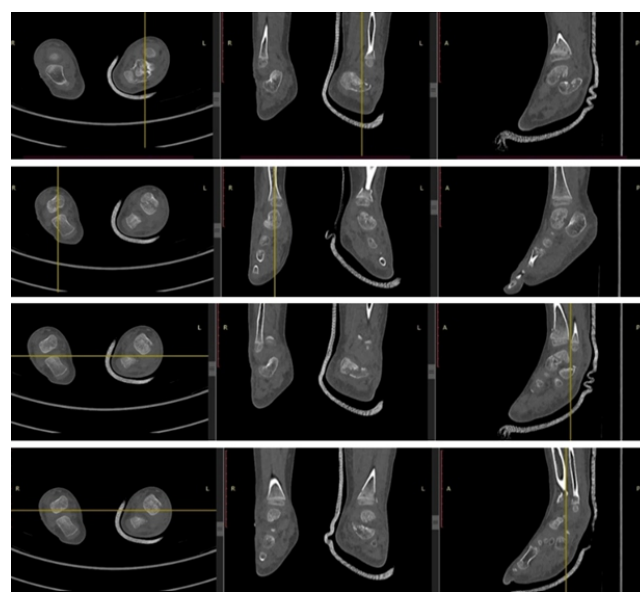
Computed tomography scan of bilateral foot and ankle – axial, sagittal and coronal views.
